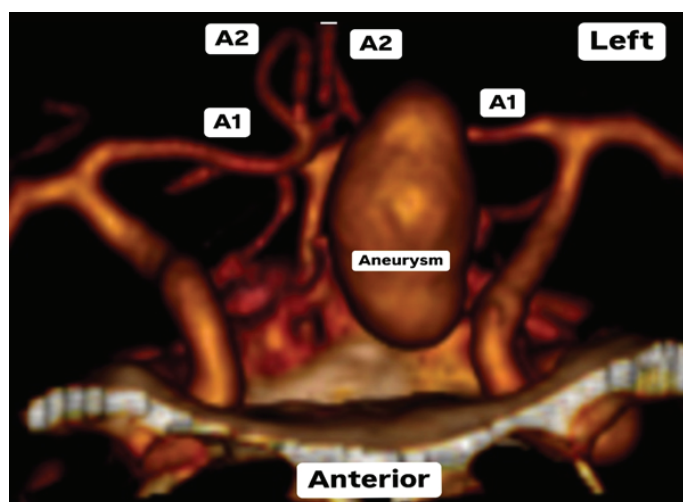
3D reconstruction from angio-CT, anteroposterior view, showing a large aneurysm in the proximal segment of the anterior cerebral artery.
